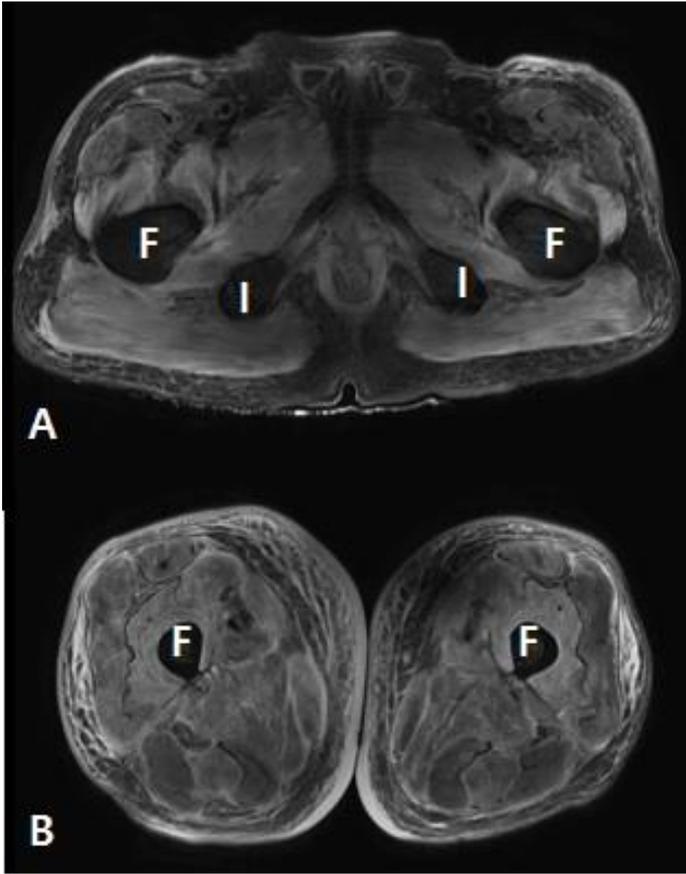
Transverse T2-weighted fat-saturated MR images of lower extremity muscles. (A) Below femoral head level (B) Mid-thigh level. The MR confirmed the clinical suspicion of dermatomyositis – (A) Severe, extensive bilaterally symmetric edema in the muscles of the pelvic girdle muscles. (B) Subcutaneous edema at medial side of thigh. F = femur, I = ischium.
